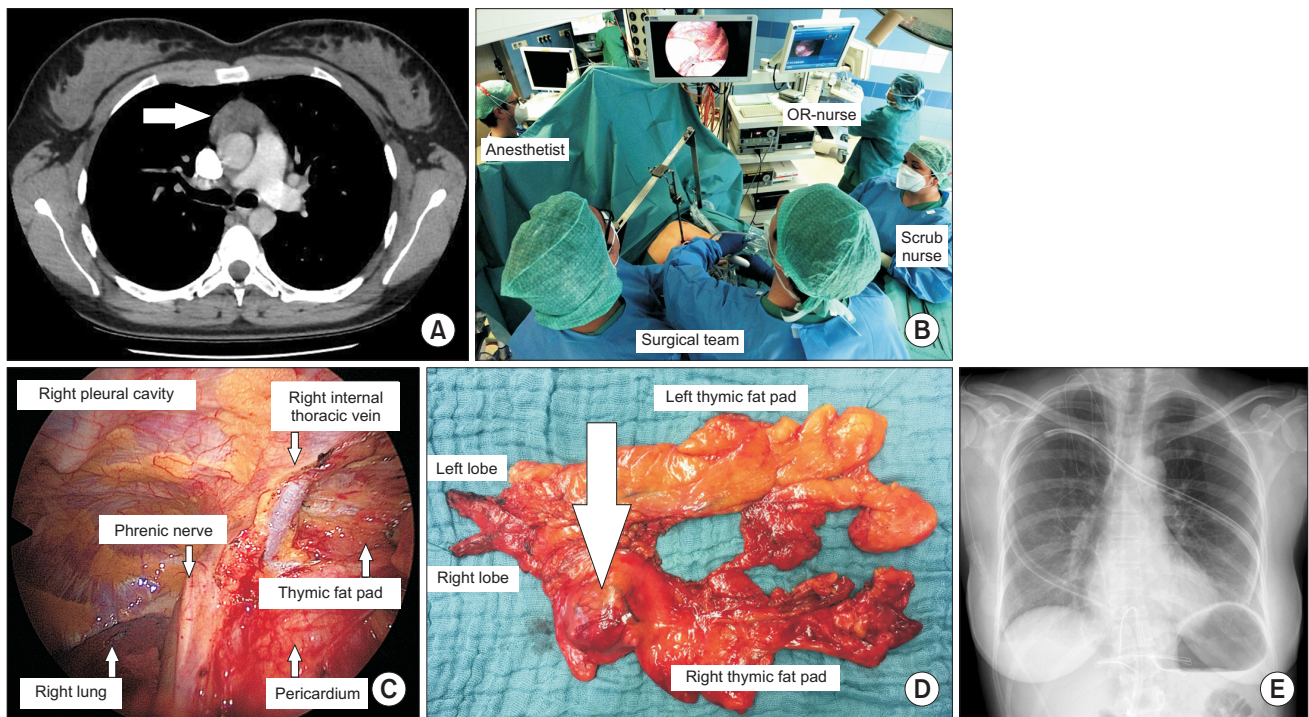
(A) Representative preoperative computed tomography scan presenting the thymic mass (arrow). (B) Arrangement of the surgical team (surgeon with the assistant on the patient's right, scrub nurse on the opposite side). (C) Thoracoscopic image: dissecting the pericardial fat pad alongside the phrenic nerve, offering straight access to the junction between the innominate vein and the superior vena cava in order to dissect and divide the thymic veins. (D) Representative thymic mass (arrow) and surrounding thymic fat tissue. (E) Representative postoperative X-ray demonstrating the position of the chest tube, which makes a sweeping arc from the right into the left chest cavity.
